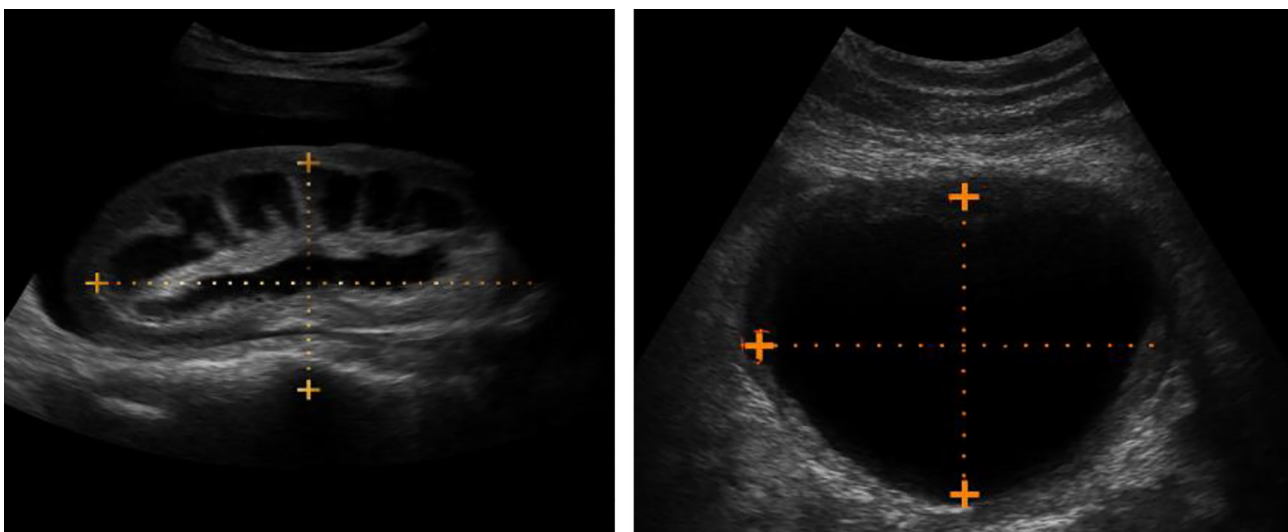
Abdominal and Pelvic Ultrasonography
